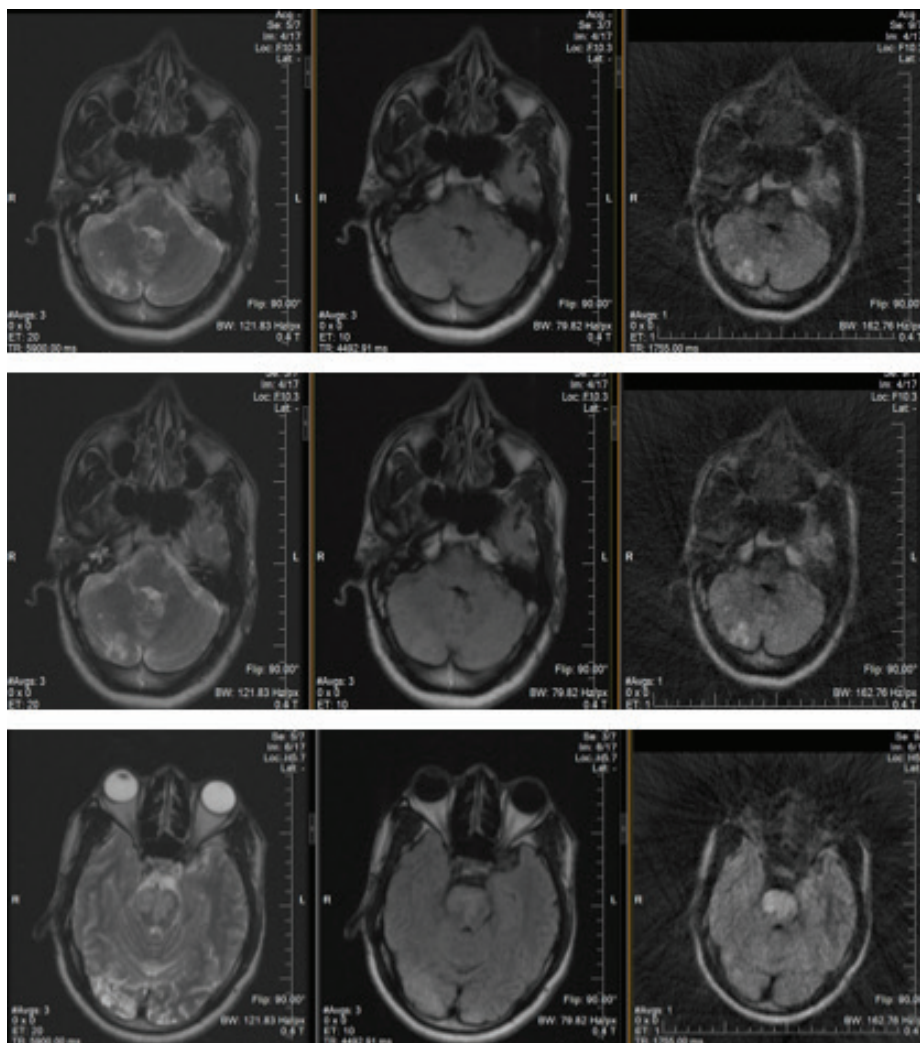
MRI of the brain showing multiple T2/FLAIR hyperintensities with restricted diffusion involving the right cerebellar hemisphere, medulla, and pons, consistent with acute multiple ischemic infarcts consistent with a small vessel/lacunar distribution. The absence of watershed (border-zone) infarcts effectively ruled out systemic hypotension or low-flow states as the primary cause of the stroke.
